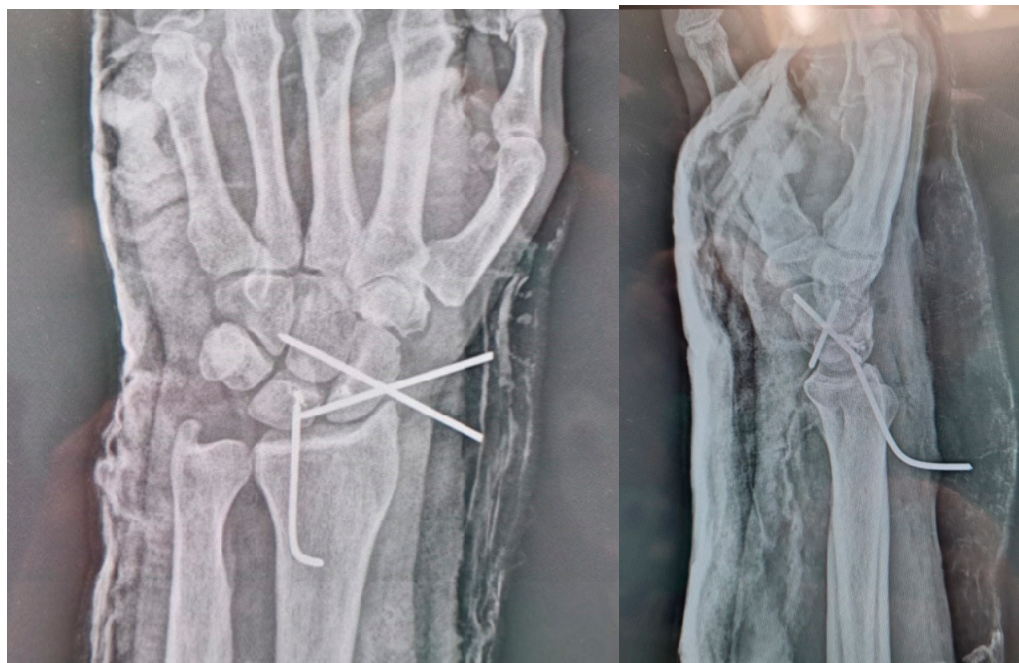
Post-operative AP and LL X-rays.
